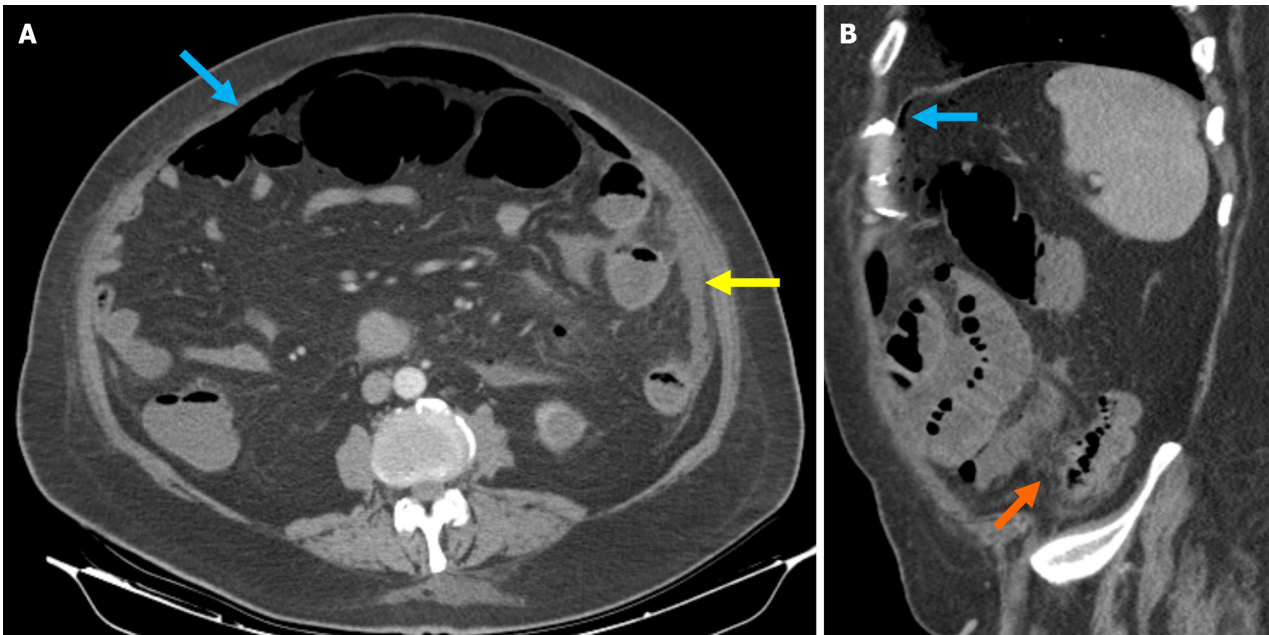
Sartelli stage 4 diverticulitis. A: Axial reformatted contrast-enhanced computed tomography (CT) image including widespread intraabdominal free air (blue arrow) and free fluid (yellow arrow), more prominently around the left colon; B: Sagittal reformatted contrast-enhanced CT image also included widespread intraabdominal free air (blue arrow). Pericolic fat stranding and inflammatory changes in the pericolic fat (orange arrow) were also observed, indicative of diverticulitis. Surgical intervention confirmed perforated diverticulitis originating from the left colon.
